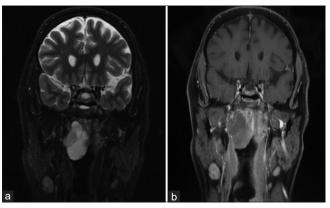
(a and b) MRI showed a well-demarcated cystic mass occupying the half right lateral wall of the nasopharynx. MRI: Magnetic resonance imaging
